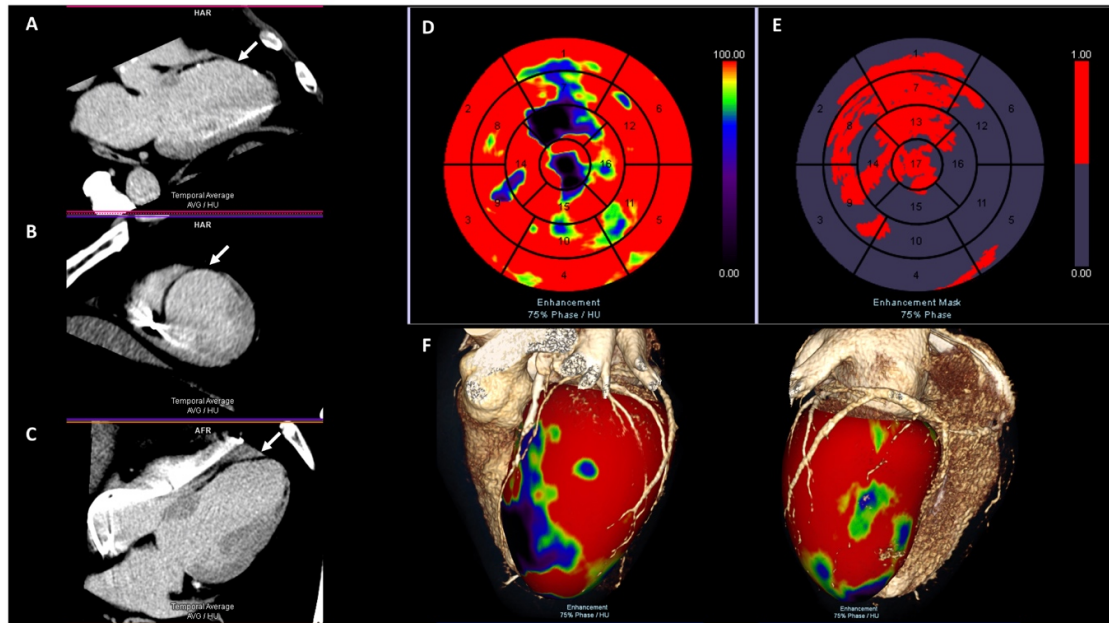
Cardiac CT scar analysis
